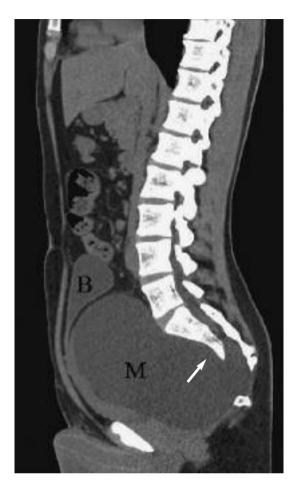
CT-scan of the abdomen and pelvis, showing a large pelvic mass (M) in direct communication with the spinal canal through a defect in the anterior sacrum (arrow). The bladder (B) is pushed anteriorly.
